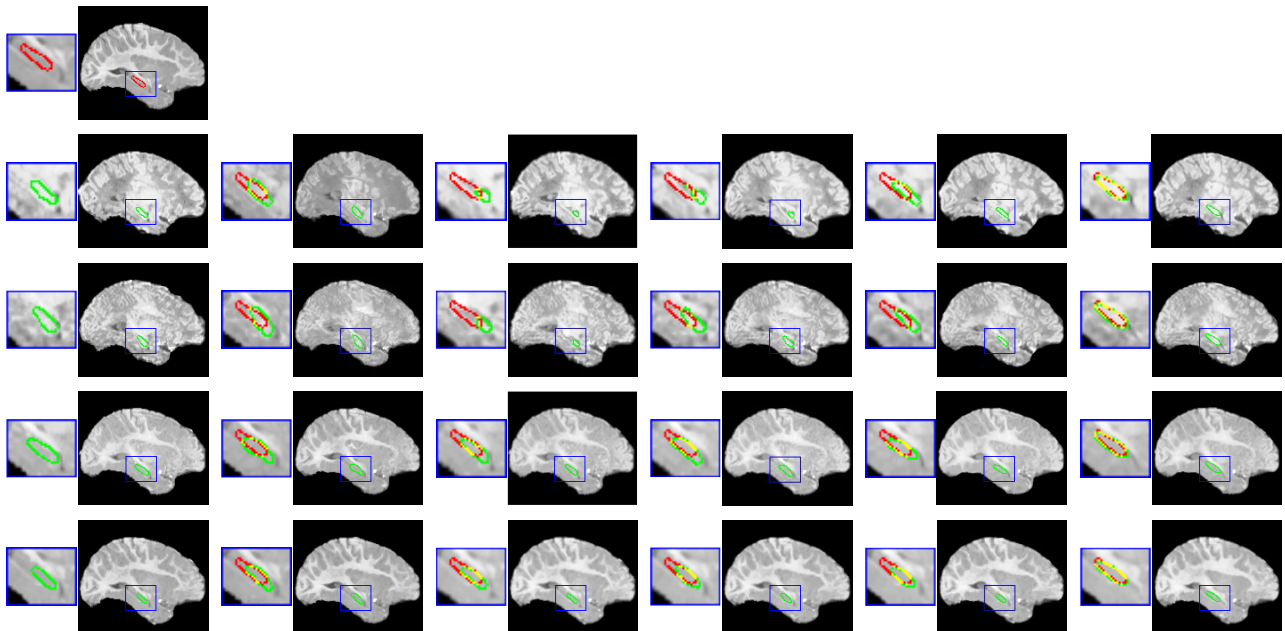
Visualization of the intrasubject registration of T1-weighted MR images. We present intrasubject registration results from 2-week-old, 3-, 6-, and 9-month-old to 12-month-old infant brain MR images from the second row to the fifth row, respectively. The top sagittal slice is from a 12-month fixed image, and the slices in remaining four rows from left to right are a moving image and warped images by Demons, MI, SyN, LRG and our method. In this figure, the red color denotes the fixed hippocampal contours, the green color denotes the moving or warped contours, and the yellow denotes the overlap contours between the fixed and the warped contours. Our proposed method can realize the largest hippocampus overlaps (shown in the last column).
